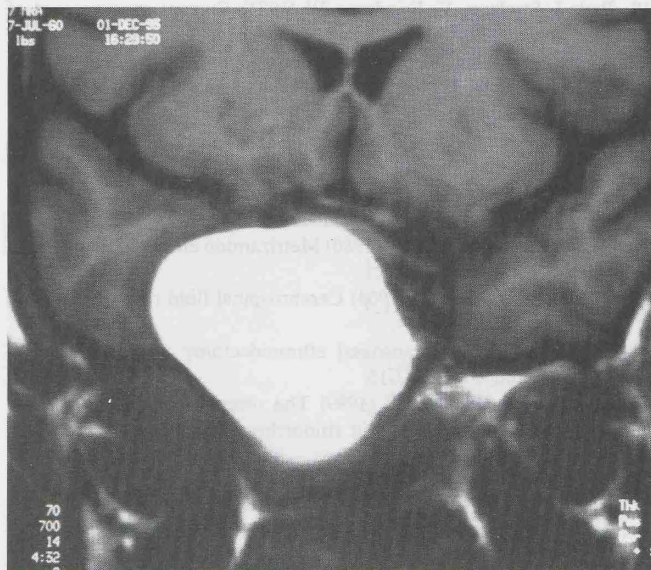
Coronal MRI-view of a sphenoid sinus mucocele extending into the cavernous sinus and anterior cranial fossa.
